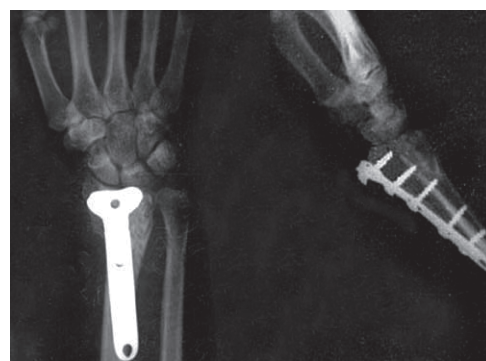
Radiographs on PA and lateral planes, showing bone union after 14 weeks of surgical treatment of pseudoarthrosis of distal radius fracture in patient number 4.
